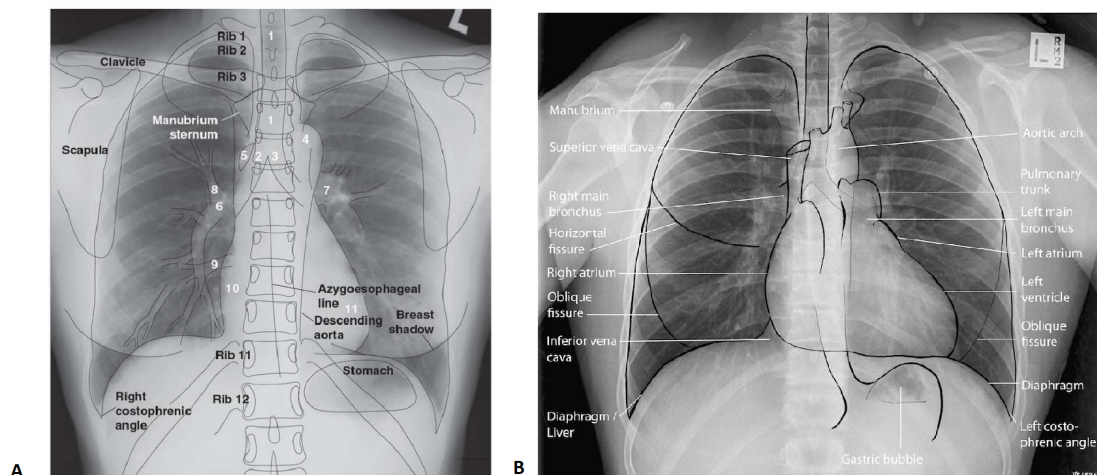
Normal anatomic structures presented in a Posteroanterior Chest Radiograph: A-(1) trachea, (2) right mainstem bronchus, (3) left mainstem bronchus, (4) aortic “knob” or arch, (5) azygos vein emptying into superior vena cava, (6) right interlobar pulmonary artery, (7) left pulmonary artery, (8) right upper lobe pulmonary artery (truncus anterior), (9) right inferior pulmonary vein, (10) right atrium, (11) left ventricle, and the other labelled structures [5]; B- Another example of a labelled PA CXR image with normal anatomy [6].
